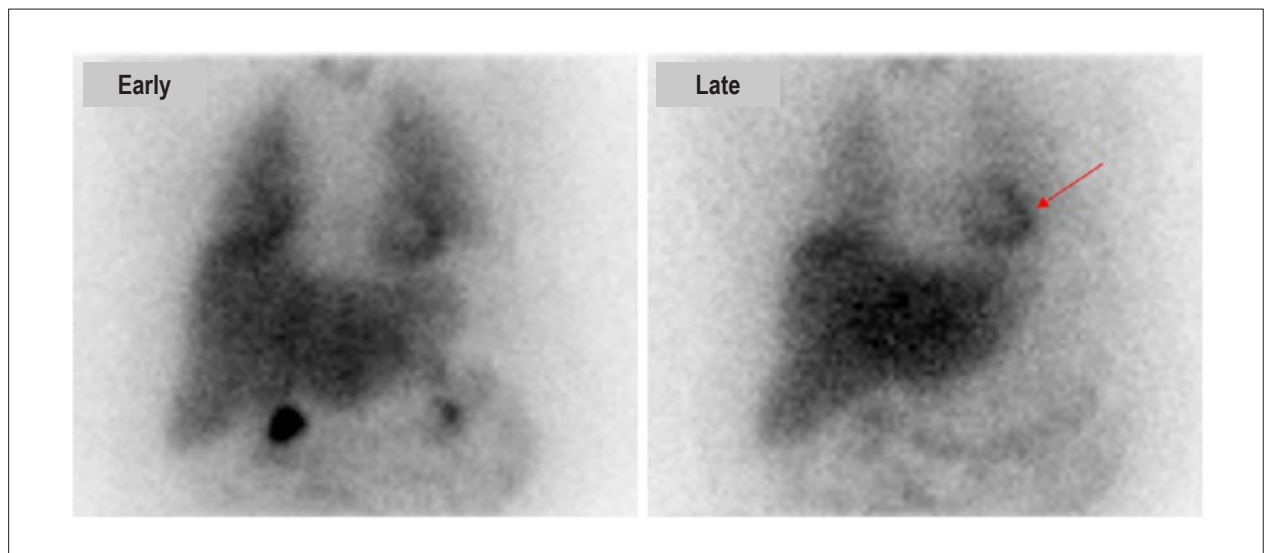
Cardiac scintigraphy with MIBG-¹²³I showing normal radiopharmaceutical uptake in the cardiac area (arrow), which denotes preserved cardiac sympathetic activity. Black and white images of the anterior thorax, acquired approximately 15 minutes (early) and 4 hours (late) following intravenous injection of the radiopharmaceutical MIBG-¹²³I.
